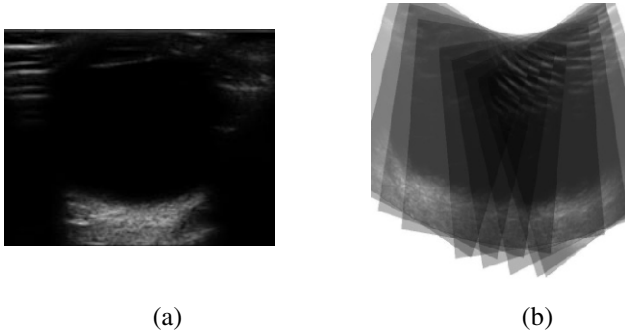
(a) An example 2D ultrasound image of the posterior segment of the eye. (b) Ultrasound frames transformed in the coordinate system of the eye for a set ($n=15$) of eye gazes.
